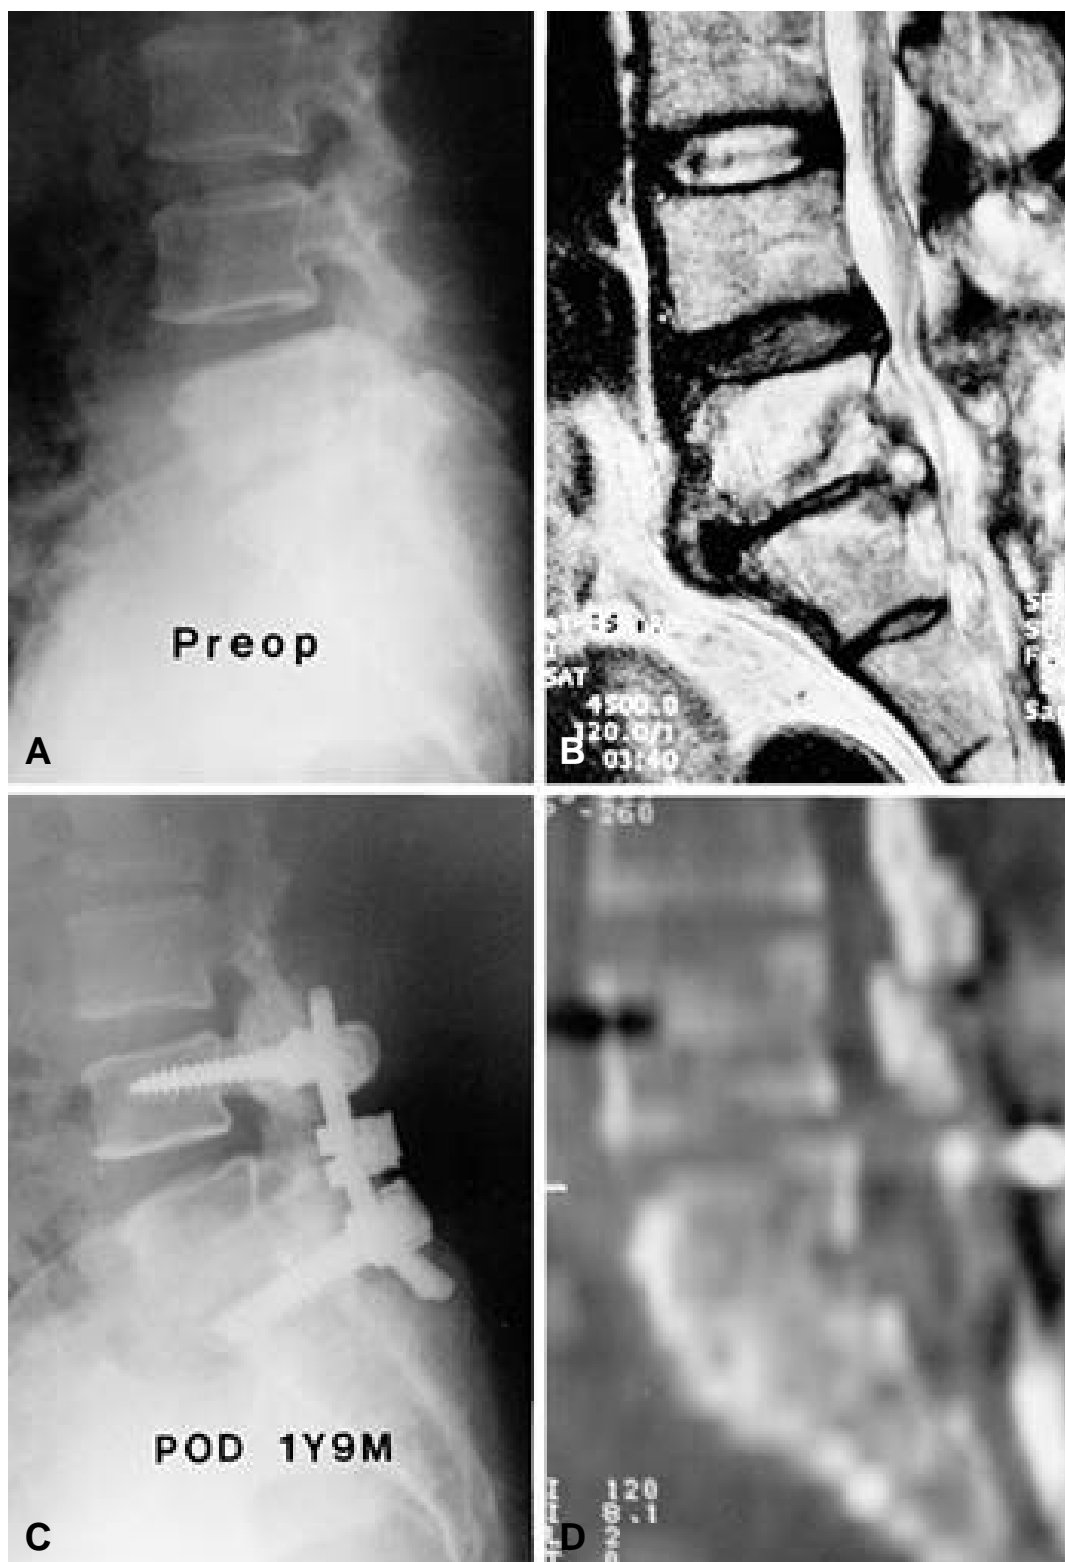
Lateral radiographs shows L5-S1 disc space narrowing and irregular end plates.
